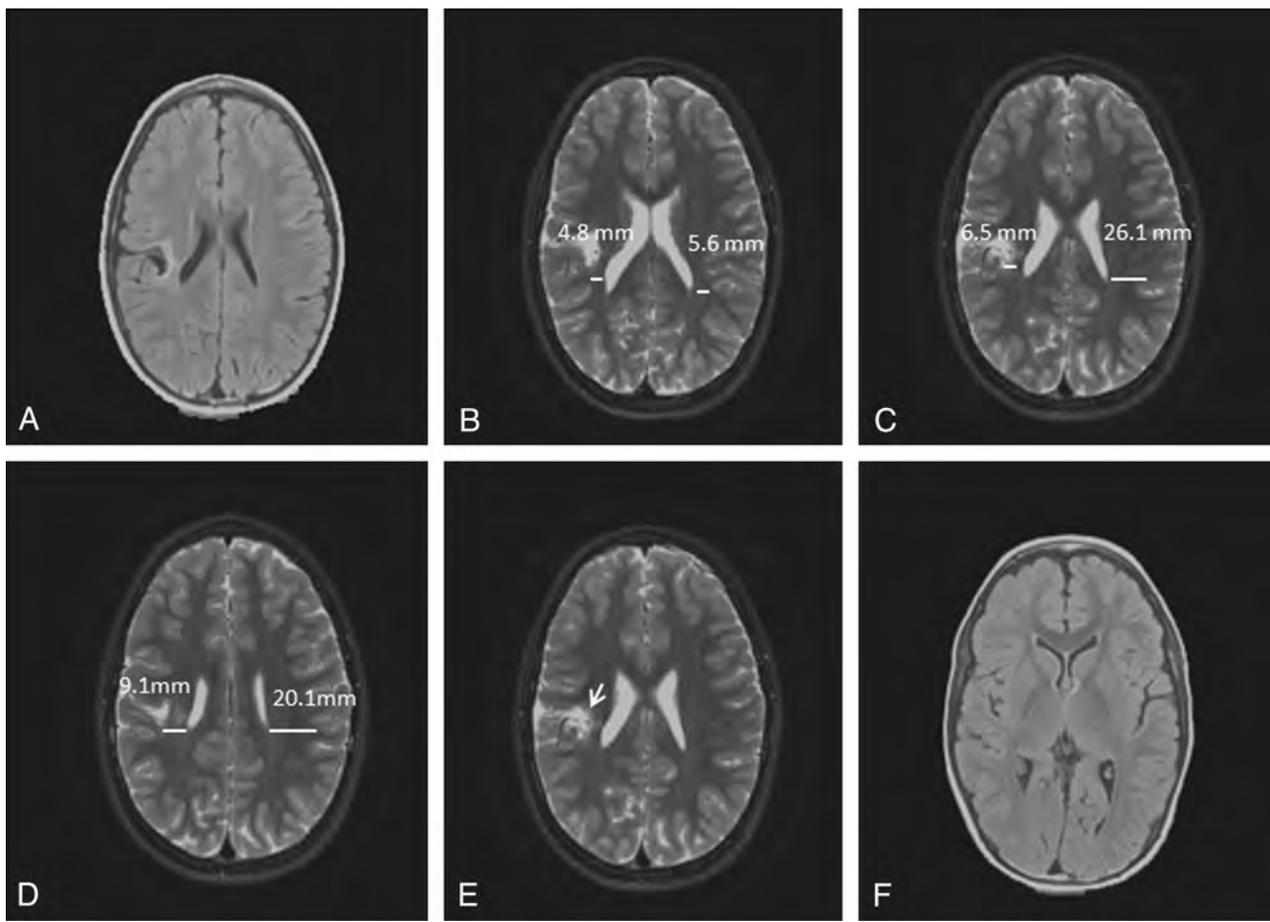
A series of axial T2-weighted images from a 7-year-old boy with left hemiplegia and MACS score of 1, with prematurity-related brain injury (periventricular leukomalacia + focal infarct). *A*, Right-sided periorlandic encephalomalacia involving frontal and parietal lobes (2 points); white matter changes include gliosis (1 point), no cystic changes. *B–D*, Assessment of white matter volume loss: the width of white matter was measured in the affected area and compared with the contralateral side, calculating percentage of volume loss. At least 3 measurements were performed and averaged; in this case, the average was in the range of moderate volume loss (40%–60%) (2 points). *E*, Presence of cortical gray matter changes (1 point). *F*, No involvement of deep gray matter and major white matter tracts. The total score was 6.
